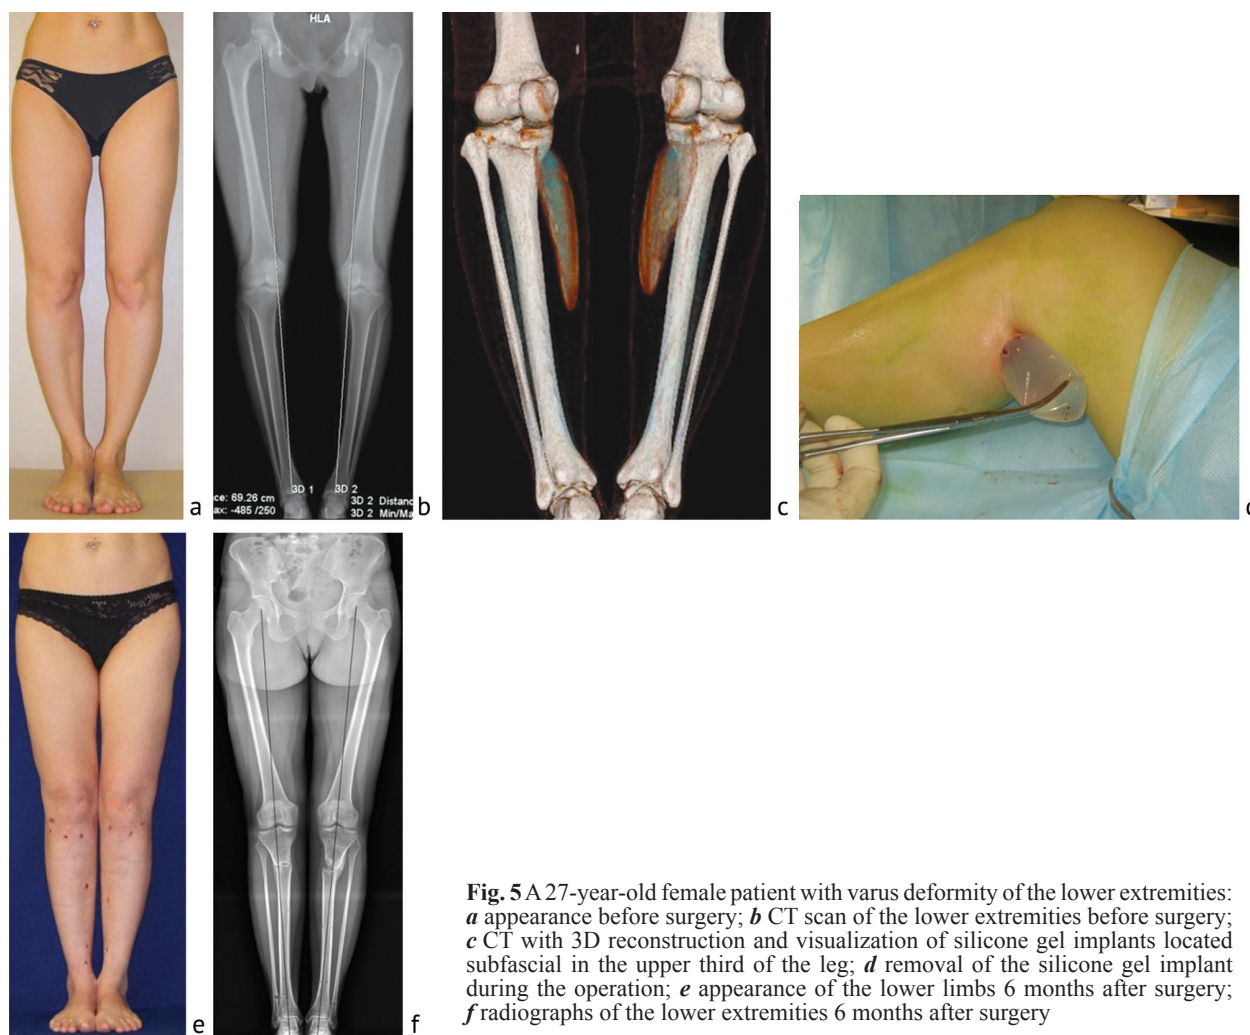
A 27-year-old female patient with varus deformity of the lower extremities: *a* appearance before surgery; *b* CT scan of the lower extremities before surgery; *c* CT with 3D reconstruction and visualization of silicone gel implants located subfascial in the upper third of the leg; *d* removal of the silicone gel implant during the operation; *e* appearance of the lower limbs 6 months after surgery; *f* radiographs of the lower extremities 6 months after surgery
